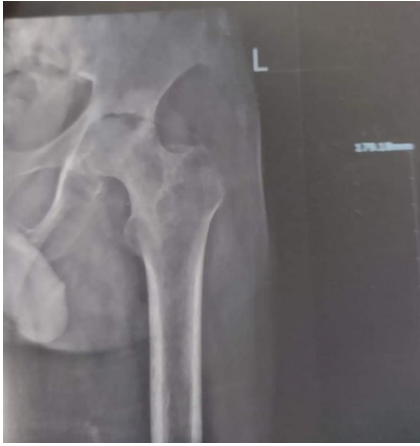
X-ray of the left hip, showing OA hip.
